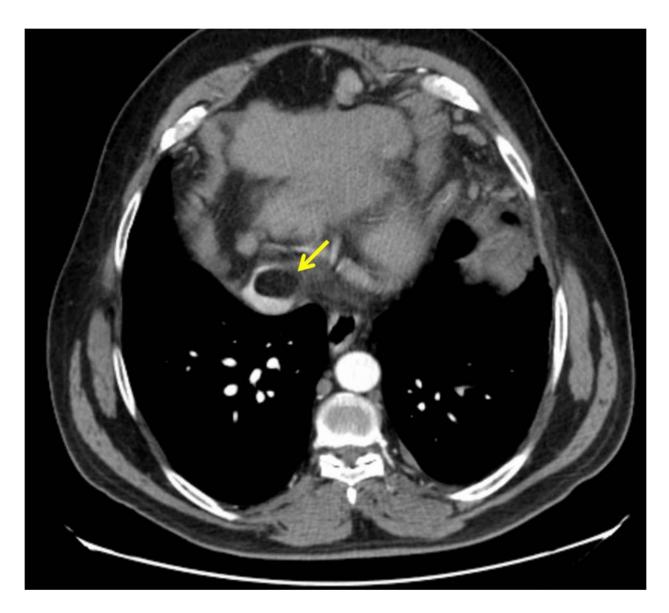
Juxtacaval fat. CT scan shows a fat-containing lesion that appears to be within the lumen of the IVC (arrow). Continuity between the juxtacaval fat and paraesophageal fat can often be seen (not shown).
